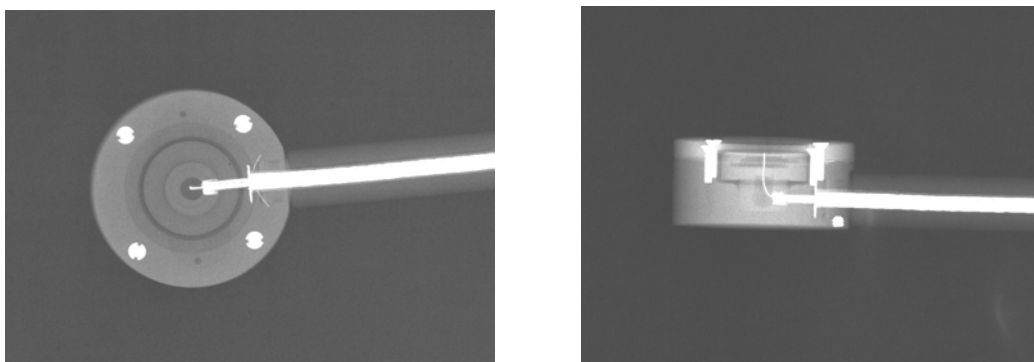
Radiographs of an Exradin A10 type ionisation chamber
